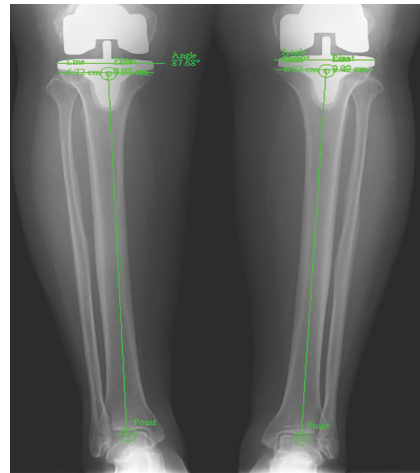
Tibial tray alignment with tibial shaft axis measured in the coronal plane in postoperative radiographs.
